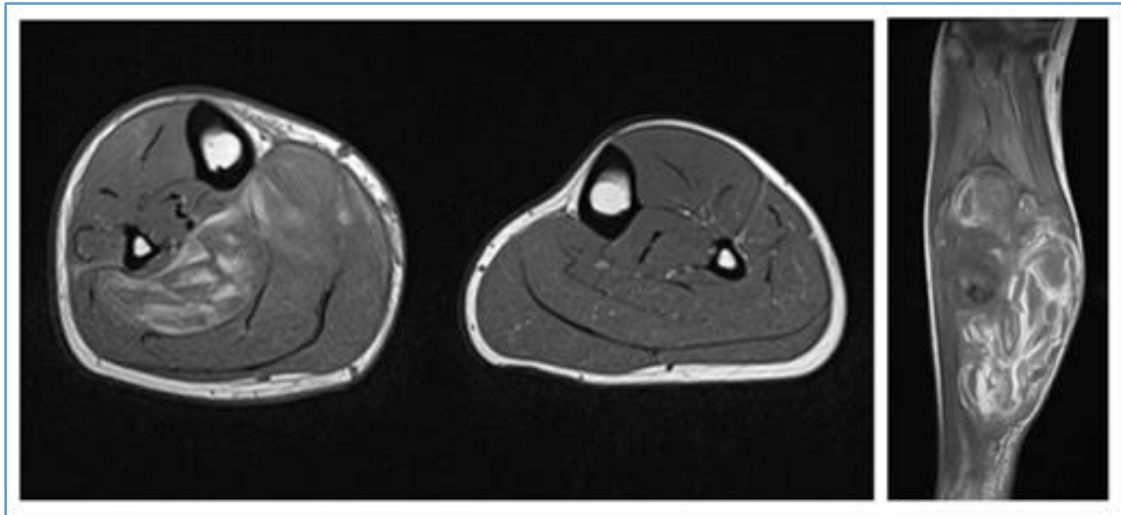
Gadolinium enhanced; T1-weighted MRI shows heterogeneous low to intermediate signal intensity. Heterogeneously mixed intensity signals on the coronal view(right) shows expansion of hematoma in medial, superior, and superficial directions.
